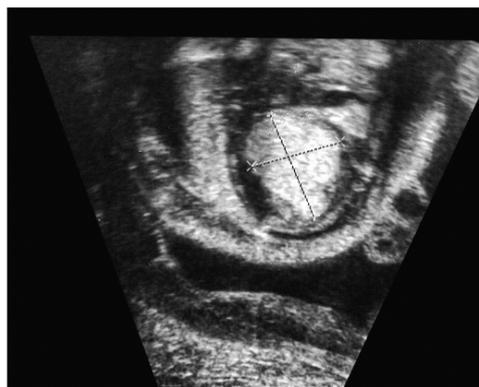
Fetal echocardiography showing the rhabdomyoma in the interventricular septum.
